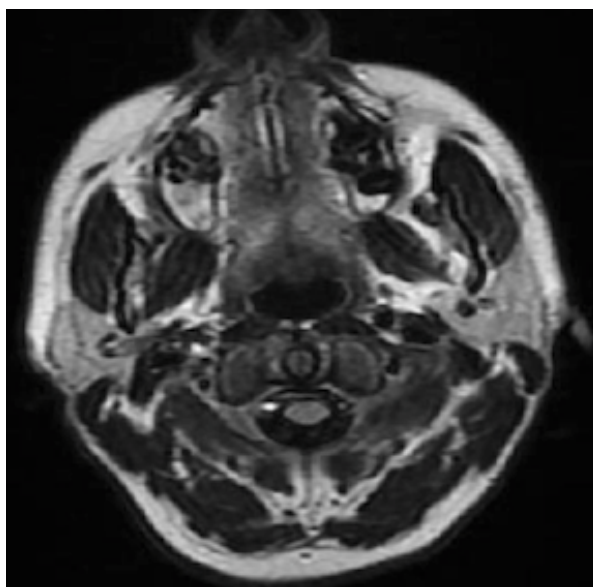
MRI of the Brain: There is no restricted diffusion to suggest acute ischemia. Ventricles size and contour appropriate. There is no mass, midline shift. No hemorrhage is seen. There is no focal parenchymal signal abnormality identified. After the injection of contrast there is no abnormal enhancement. Normal MRI brain without and with contrast.
